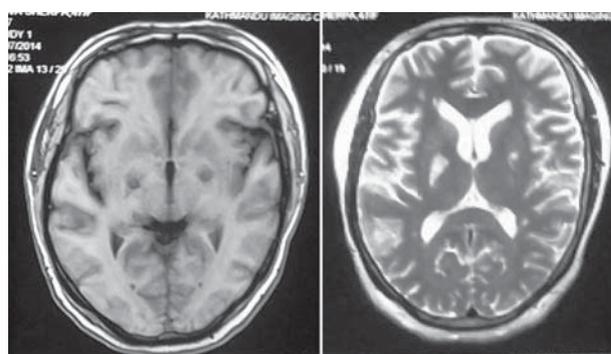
Immediate postoperative MRI Brain; T1W and T2W Axial Images
